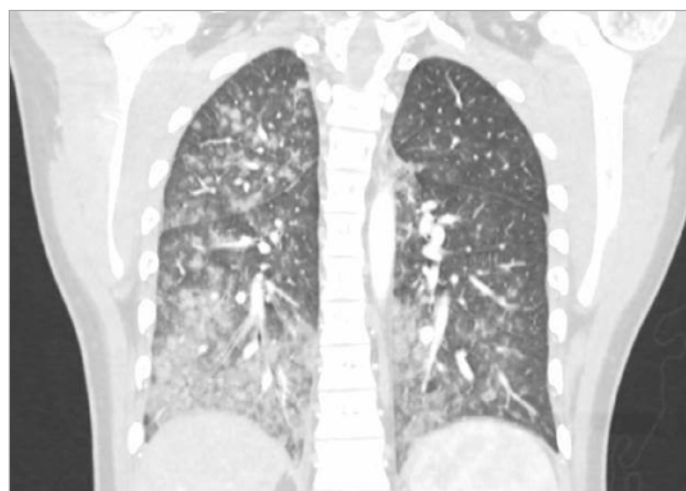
CT showing bilateral diffuse alveolar haemorrhage.
